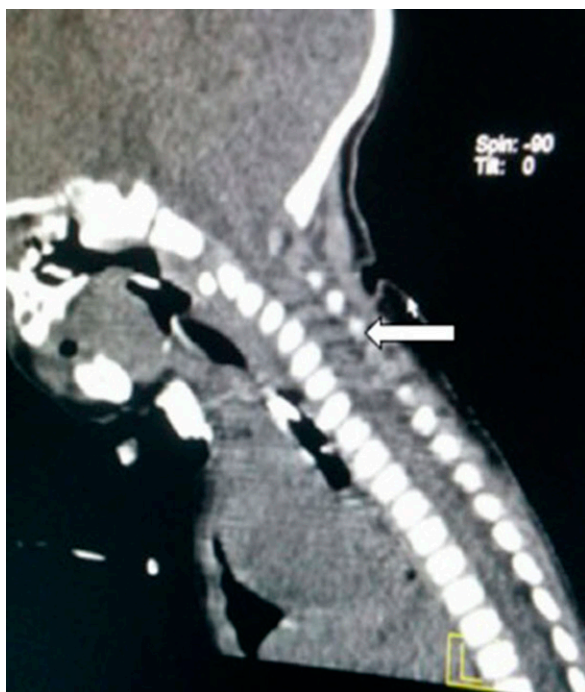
Computed tomography scan showing cervical injury.
